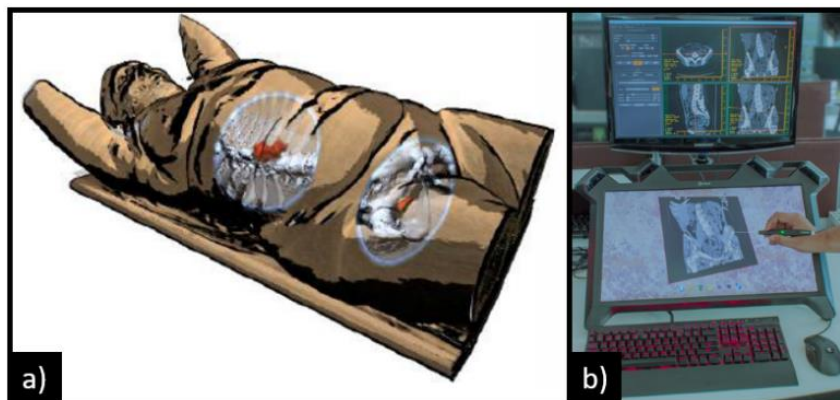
The functional PET data in red is complemented by bone and skin information of the CT(left). Hybrid interface setup with 2D (top) and 3D (bottom) screens (right). Adapted from [37][38], respectively.
